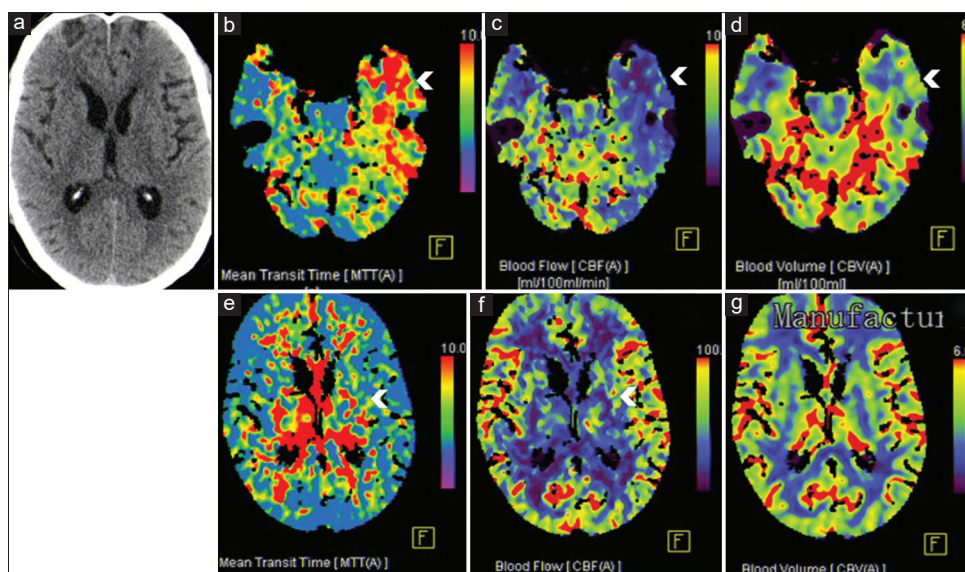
(a) Noncontrast computed tomography head showed no established acute infarct or hemorrhage. (b-g) Computed tomography perfusion images showed mismatch deficit (penumbra, white arrow head) in the left middle cerebral artery territory involving left anterior temporal lobe and internal capsule. Penumbra is defined as brain tissue with reduced cerebral blood flow, increased mean transit time and preserved cerebral blood volume
